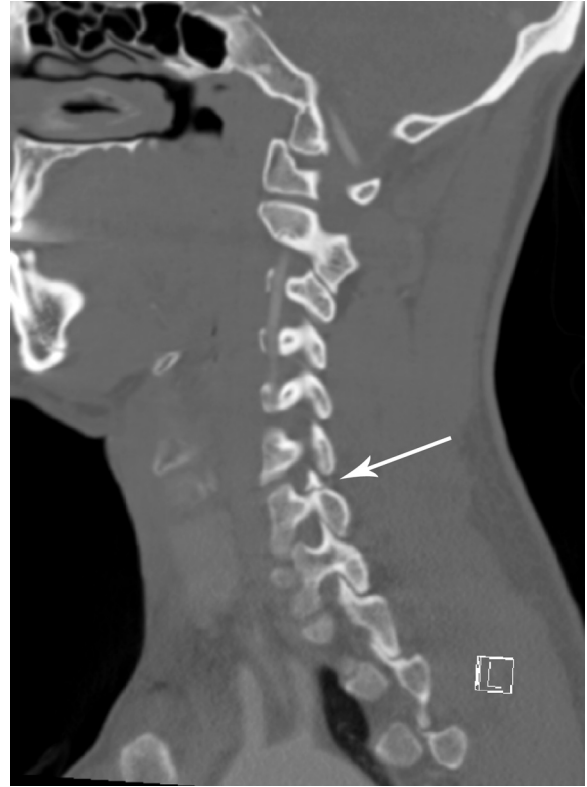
Computed tomography angiogram of the cervical spine. This image demonstrates a fracture of the superior articular process of C7.
